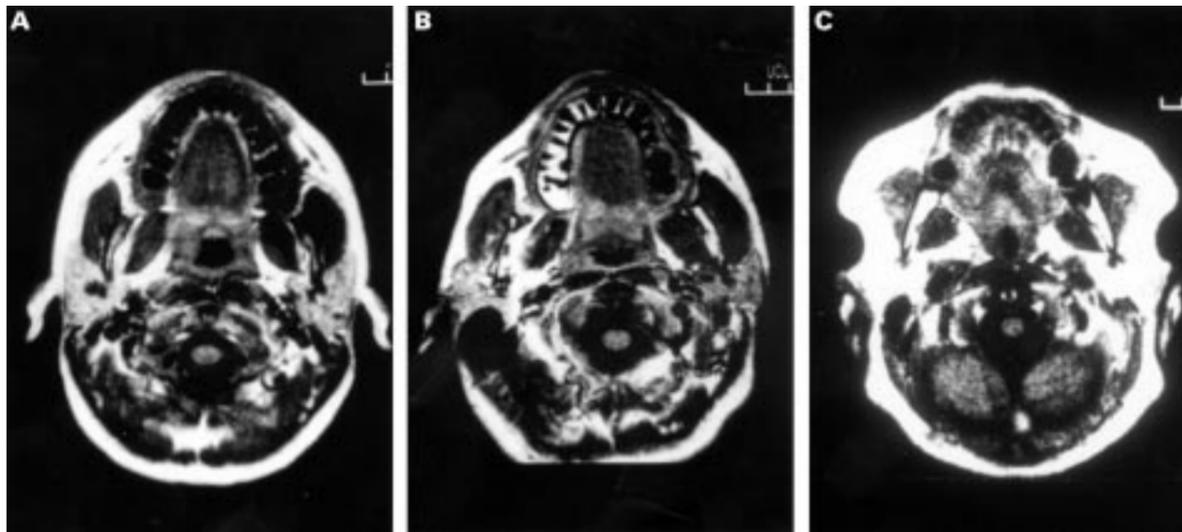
Transverse magnetic resonance images of the pharynx in (A) a normal subject, (B) a subject with simple snoring, and (C) a subject with sleep apnoea syndrome. In the normal subject the pharynx has an elliptical shape with the long axis orientated in the coronal plane. In the sleep apnoea subject, and to a lesser extent in the snoring subject, the pharynx has a round or elliptical shape with the long axis orientated in the sagittal plane. (Images courtesy of Dr DO Rodenstein.)
